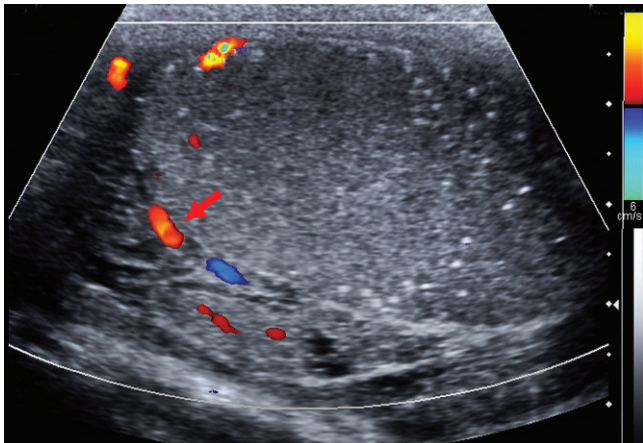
The longitudinal color Doppler sonogram of the testis shows minimal peripheral flow (arrow).
